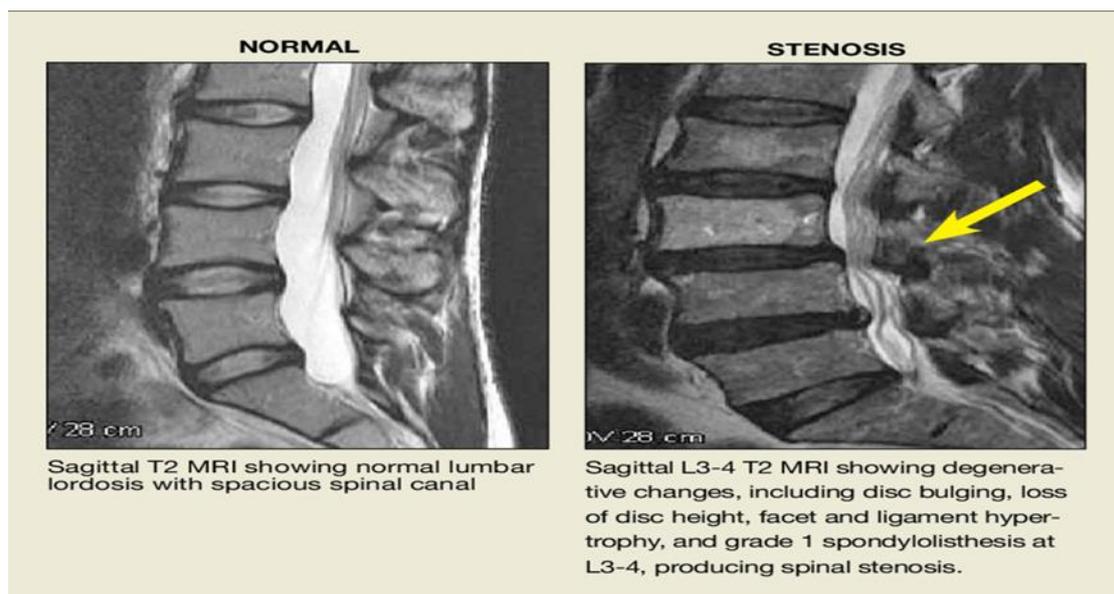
MRI of lumbar spinal stenosis (Spondylosis pattern) ⁽⁸⁾
